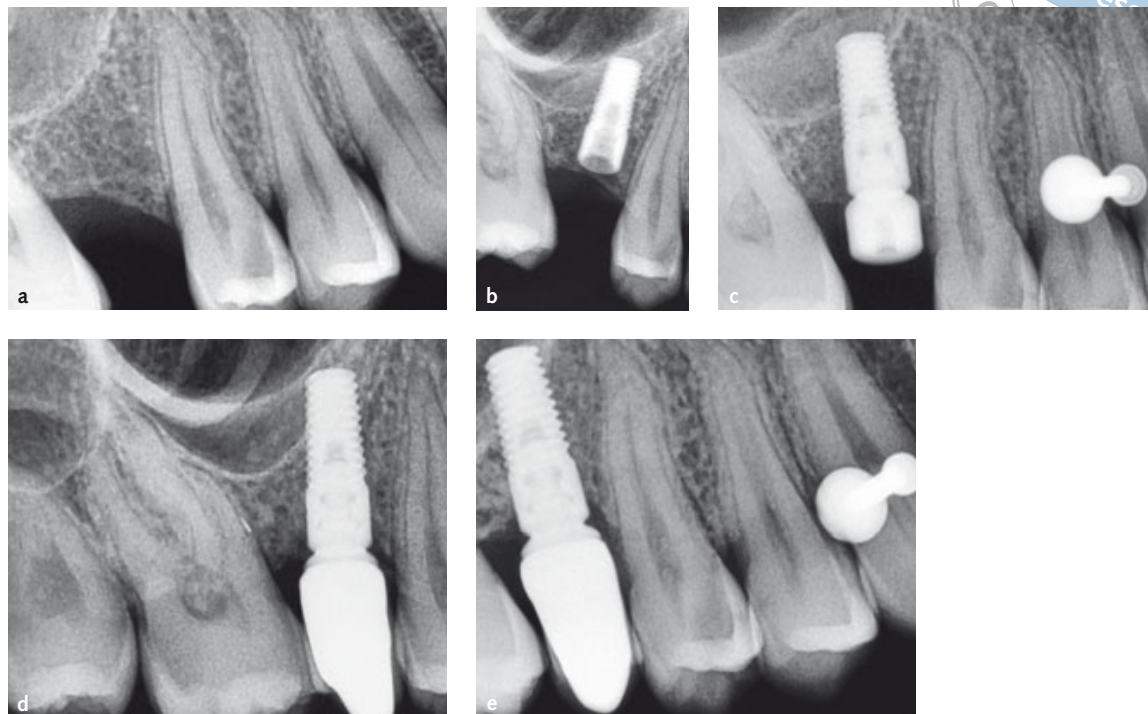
Periapical radiographs of one of the patients treated by Dr Pietro Felice; site randomly allocated to a Way Milan implant: (a) preoperative view; (b) just after implant placement; (c) at abutment connection; (d) at 4 months post-loading; (e) at 1 year post-loading. Please note the coronal portion of the implant neck with its inbuilt platform switching, which makes it easily distinguishable from the Kentron implant design.
